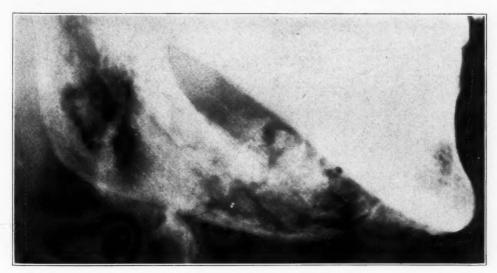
Roentgenogram made February 16.
